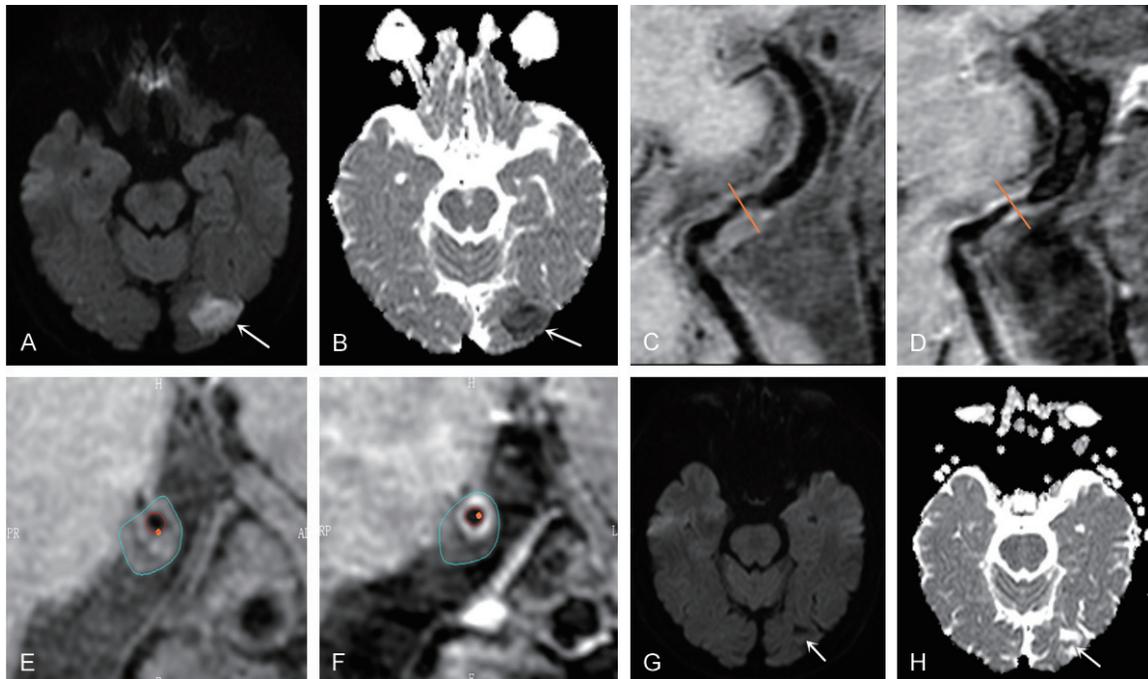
A 62-year-old symptomatic ICAD patient with severe stenosis on the BA. DWI detected a lesion with hyperintensity (A, white arrow) in the left occipital lobe, which showed hypointensity on ADC (B, white arrow). Long-axis images (C, D) reconstructed from pre- and post-contrast enhancement HR-VW-MRI volume acquisition revealed a focal plaque located at the BA. Short-axis images (E, F) were reconstructed from the pre- and post-contrast enhancement HR-VW-MRI orthogonal to the BA. The contour of the outer wall is in blue, and the lumen is in red. (G, H) Were images after re-examination. Hypointensity lesion (G, white arrow) was seen in the left occipital lobe on DWI and hyperintensity on ADC (H, white arrow).
